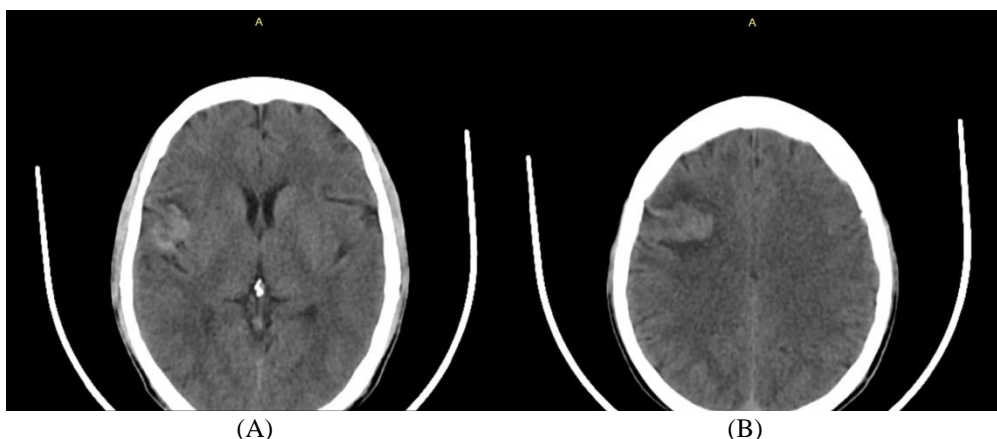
The results of a CT-head non-contrast showed a picture of bleeding in the right insular region (A) and right frontoparietal region with a picture of infarction around it (B).
